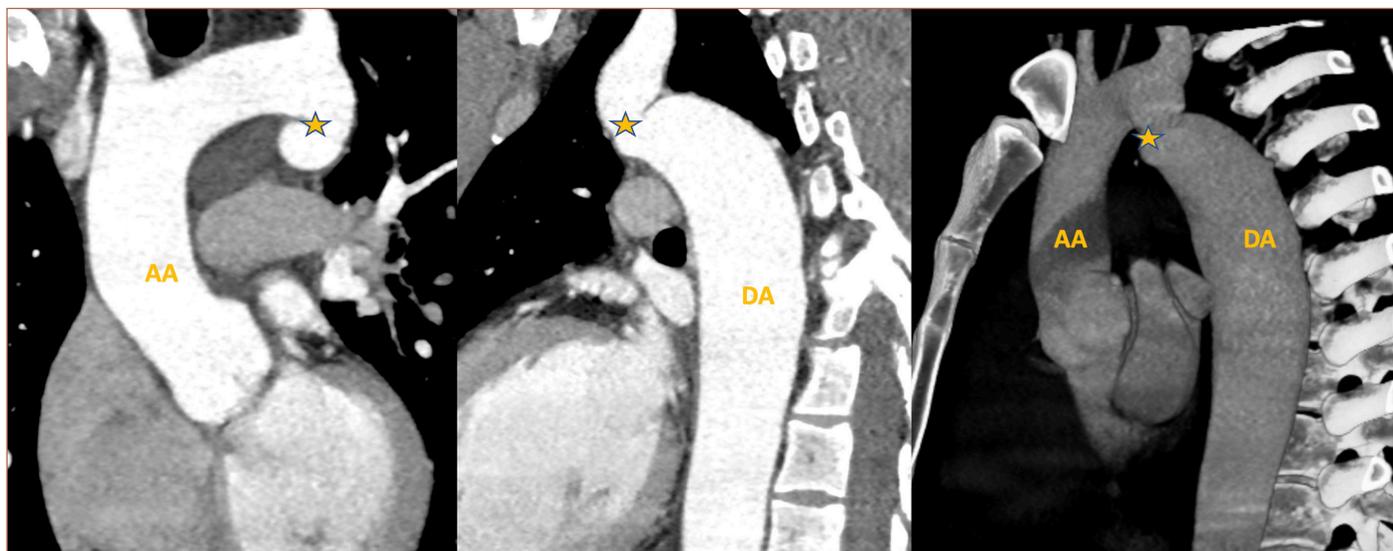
CT angiography showing an elongated and kinked aortic arch (*Elongation and buckling of the aorta)
